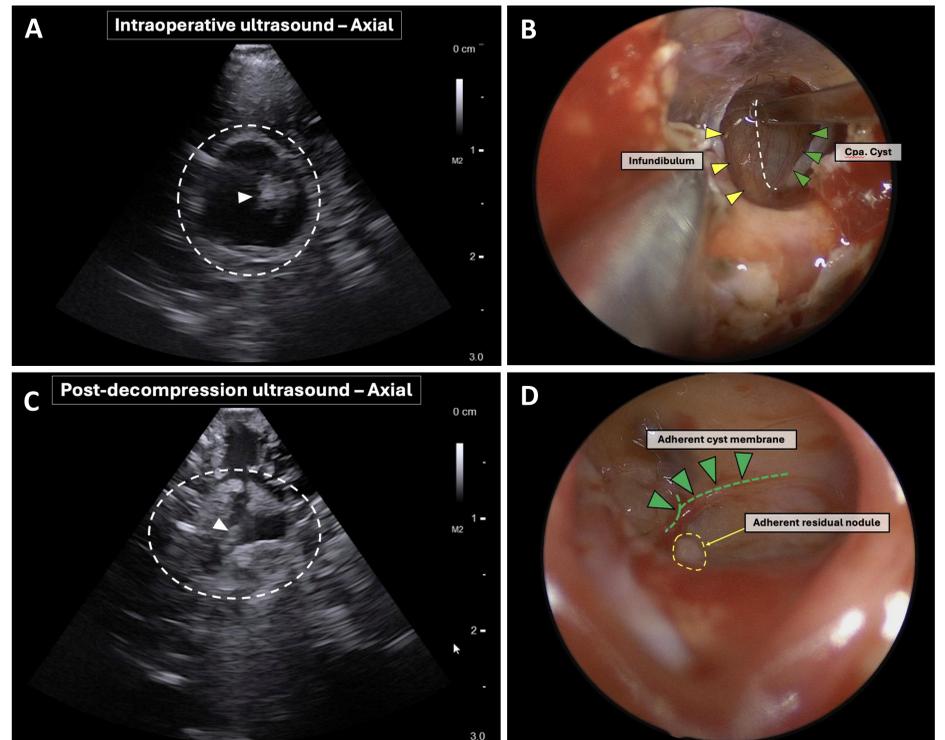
Intraoperative ultrasound view of nodular-cystic lesion pre-decompression (A) and post-decompression (C). A small nodular residual was left behind due to adherence (white arrowhead). Intraoperative endoscopic view of the infundibular incision (B) and post-decompression view (D).
